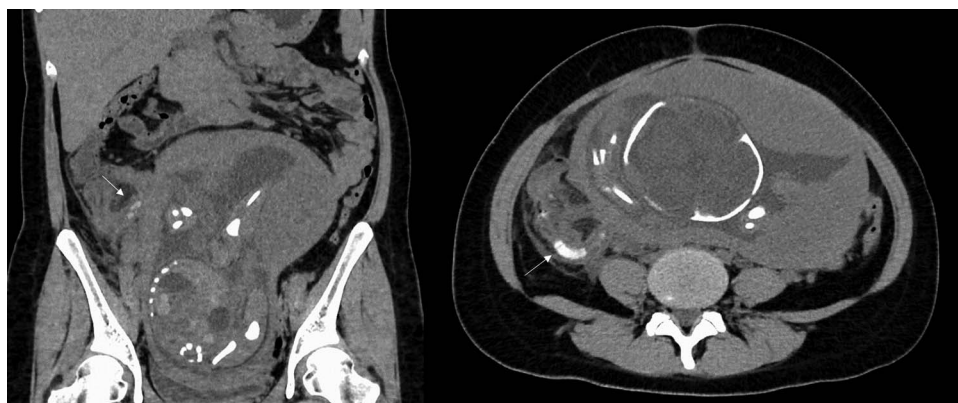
Computed tomography findings. Computed tomography revealed the gravid uterus occupying the pelvis and the swollen appendix with many fecal calculi (arrow), lying dorsal to the ileocecal region. It showed no evidence of perforation or abscess formation.
